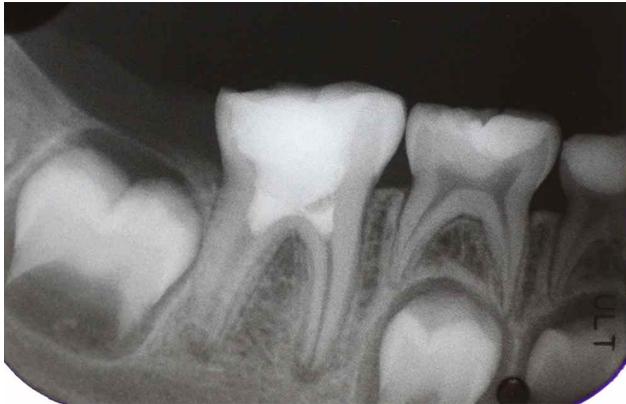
X-ray at 4 months. The evolution of distal and mesial apical root development is observed.
